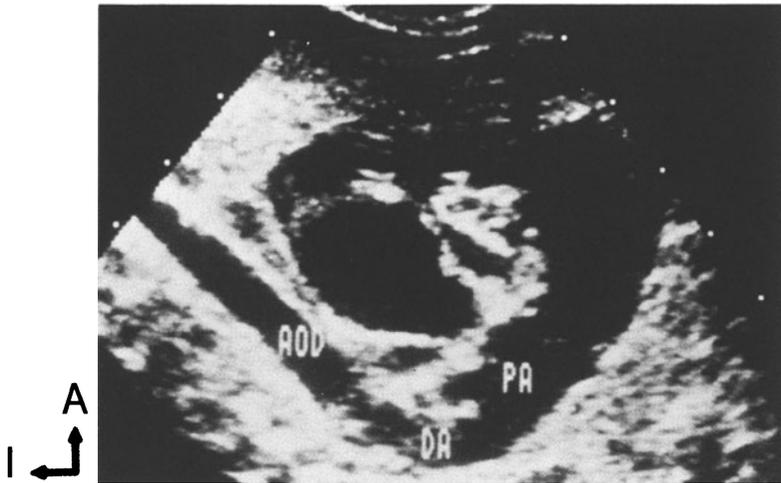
Two-dimensional echocardiogram in the subcostal short-axis view. The patent ductus arteriosus is imaged (abbreviations: *A*, anterior; *AOD*, descending aorta; *DA*, ductus arteriosus; *I*, inferior; *P*, *PA*, pulmonary artery).
